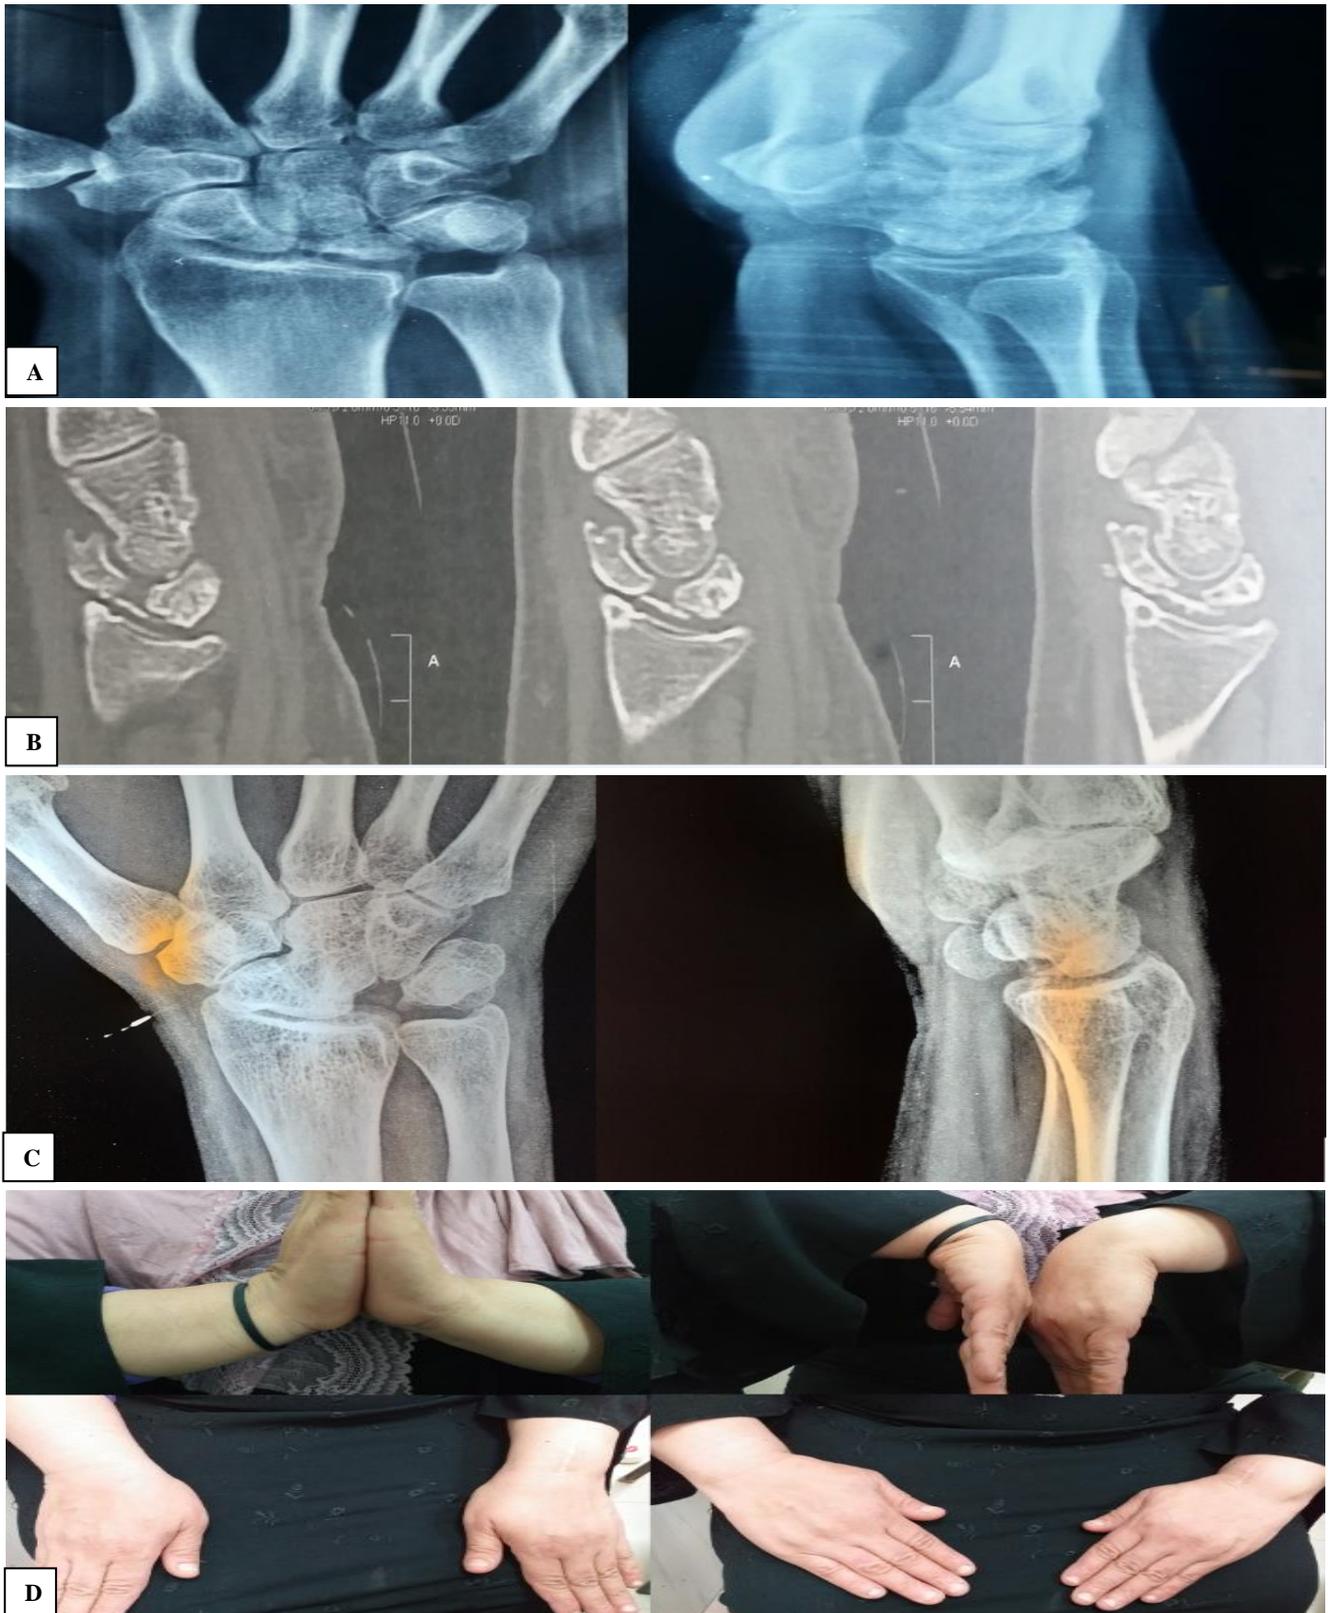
Case presentation; (A) preoperative X-ray of 37 years old housewife showed lunate collapse of left wrist; (B) preoperative CT scan showed coronal fracture of the lunate; (C) twenty four months follow-up X-ray showed scaphocapitate union and (D) twenty four months postoperative range of motion.
